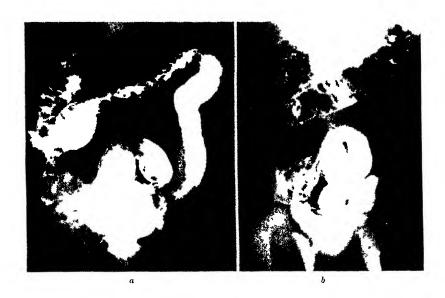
A—(a) Roentgenogram made after evacuation of the contrast (barium) enema, showing a widening in the transverse limb of the hepatic flexure caused by a large polypoid lesion in this segment (b) "Double contrast" roentgenogram showing the globular polypoid lesion projecting into the lumen of the colon
